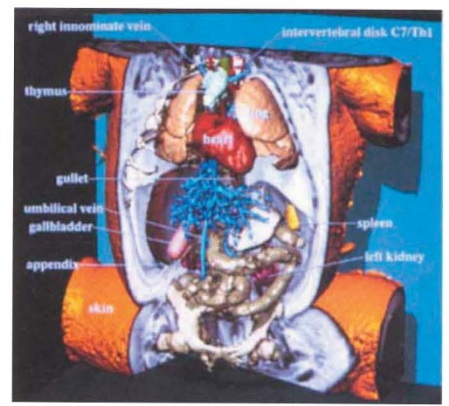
View generated with the interactive 3D atlas of a human fetus, derived from magnetic resonance imaging.
